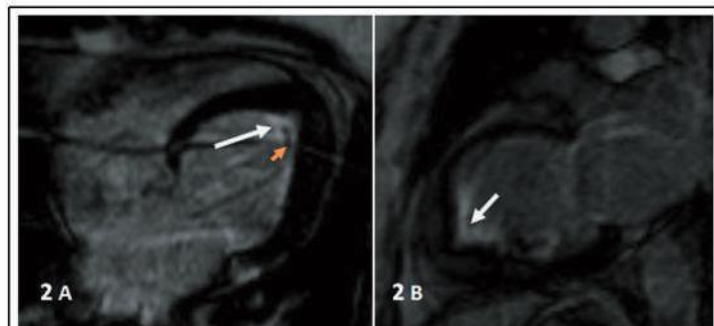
A and B: Cardiac MRI Delayed enhanced Phase sensitive inversion recovery(PSIR) image in 4 chamber and 2 chamber shows Subendocardial enhancement at the apical left ventricle(white arrow) with small thrombus/calcification (orange arrow head)in the LV apex.
